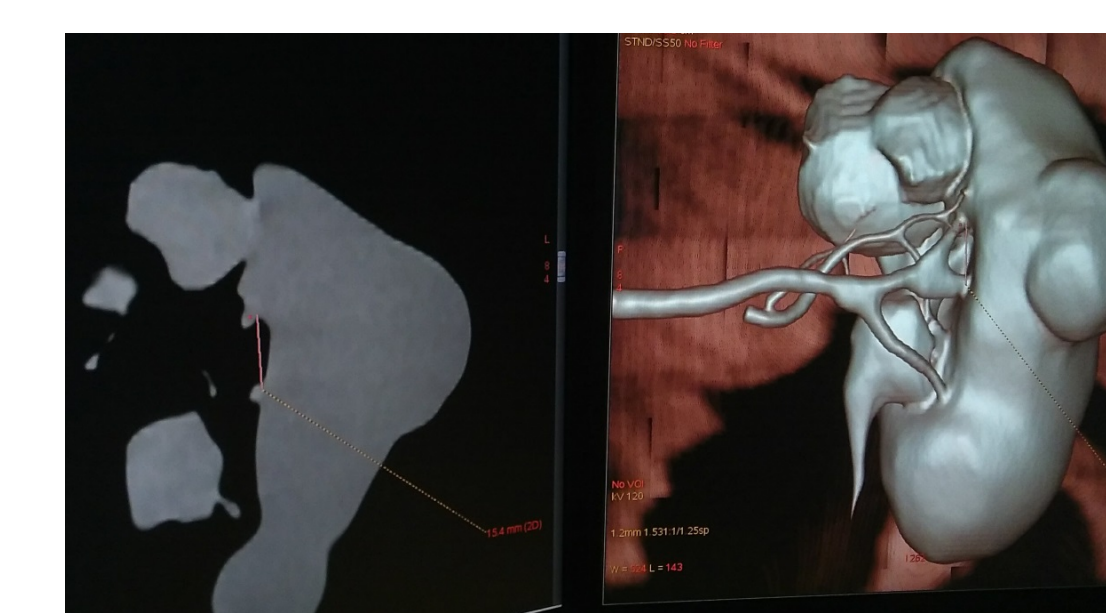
CT-slice of 3D model and volume rendering of the 3D model CT scan
